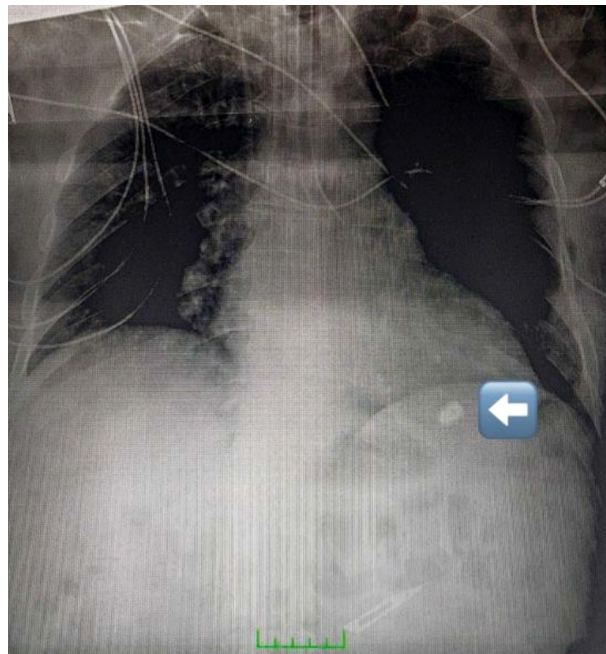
Chest radiograph of bullet in apex of right ventricle (white arrow).
